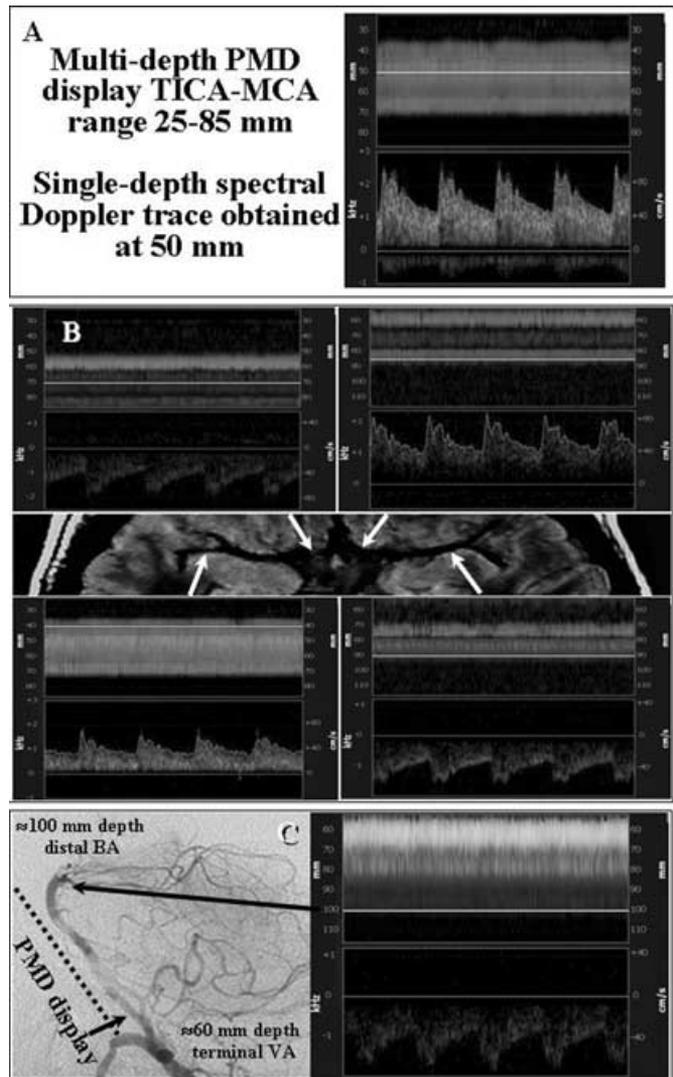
Power motion Doppler display as a window finding tool and a guide to a complete spectral Doppler examination.
